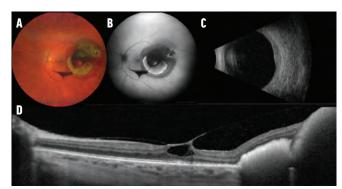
Wide-angle color fundus photography shows the choroidal nevus with fresh overlying subretinal hemorrhage, yellow, partially dehemoglobinized curvilinear subretinal hemorrhage inferiorly, and "breakthrough" subhyaloid hemorrhage in the inferior macular region (A). FAF reveals hypoautofluorescence of the fresh blood and hyperautofluorescence of the chronic blood (B). Ultrasonography confirms a shallow, domeshaped, echodense choroidal mass of 2.6 mm in thickness (C). OCT shows vitreomacular traction with cystoid macular edema, as well as subretinal and subhyaloid hemorrhage (D).
